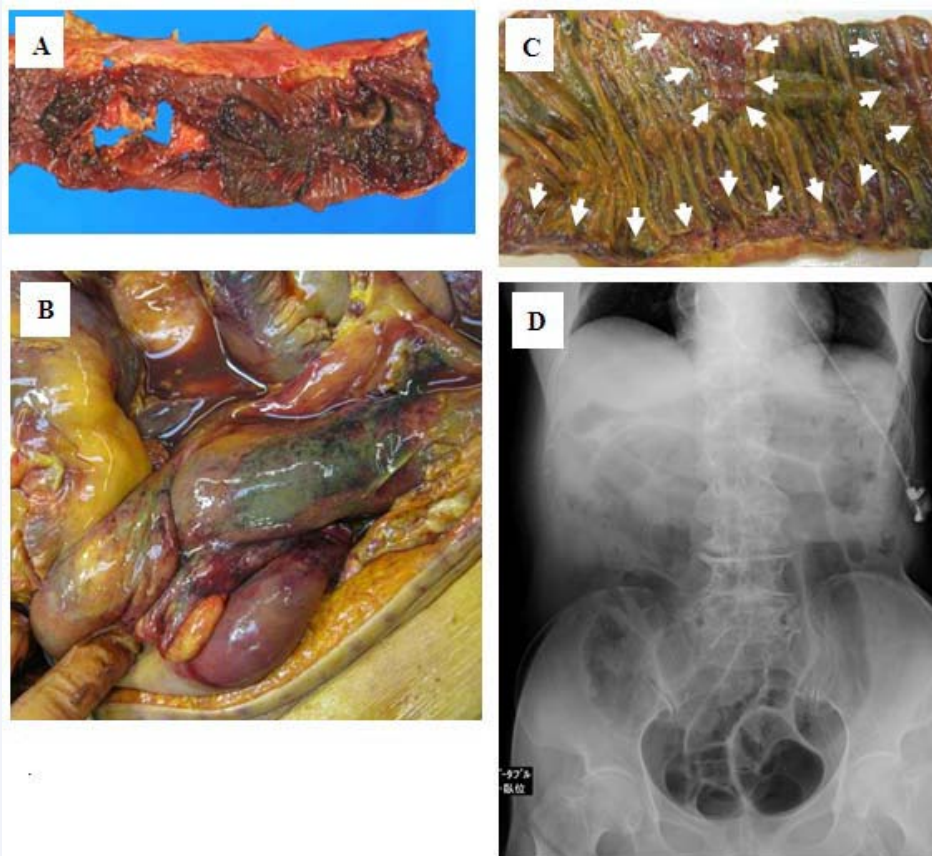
A: Perforation of the sigmoid colon seen during an operation. B: Bleeding necrosis of the intestines seen at an autopsy. C: Loss of epithelium (arrows) seen in the intestine during an autopsy. D: Expanded bowels due to paralytic ileus on abdominal X-ray on the second day after the bite. Fig. 2 was quoted from Ref. [29] with some modifications.
